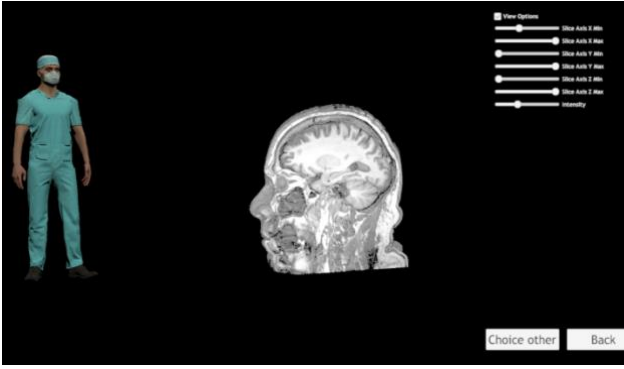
Visualization of MRI 2D medical image data in a 3D VR model.
